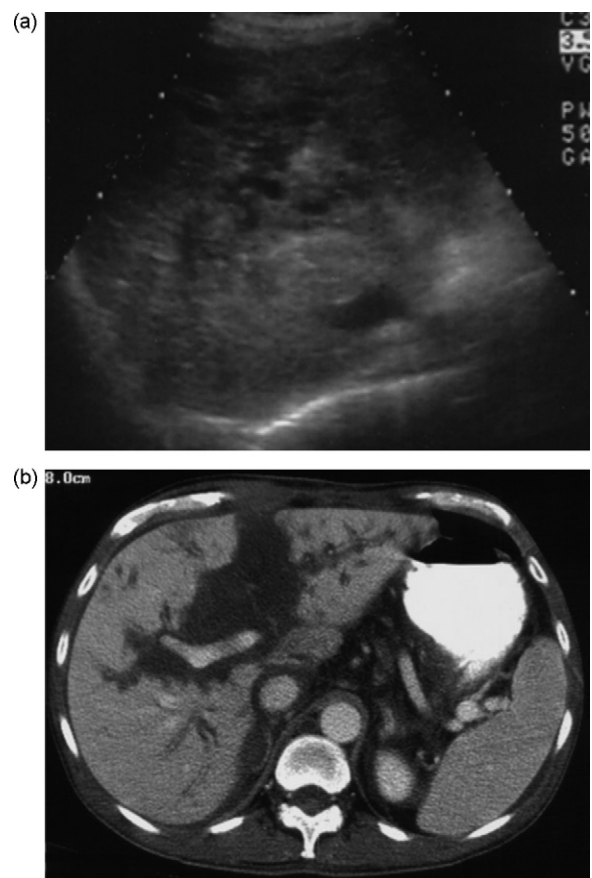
Hepatic artery thrombosis: (a) US demonstrates diffuse heterogeneous mixed echogenic change. (b) CT showing widespread periportal low attenuation change.
